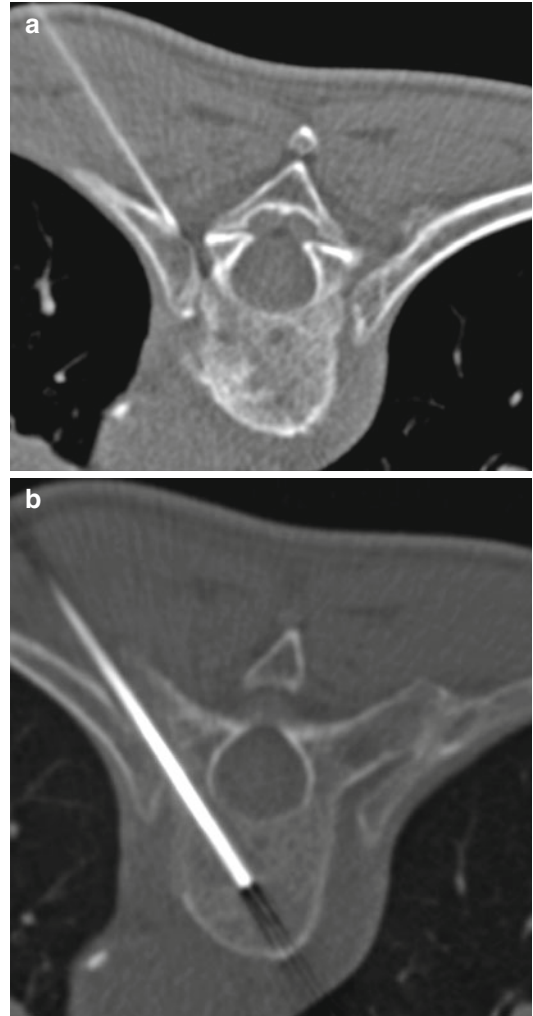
Patient (prone position) with suspicion of spondylodiscitis in the Th⁷/8 spinal segment. Preinterventional CT showed small osteolytic defects close to the upper end plate of thoracic vertebra 8. After local anesthesia with a 22-G needle (a), a 12.5-G bone biopsy needle was introduced through the left costovertebral joint (b). Microbiological analysis revealed spondylodiscitis due to a *Staphylococcus aureus* infection
